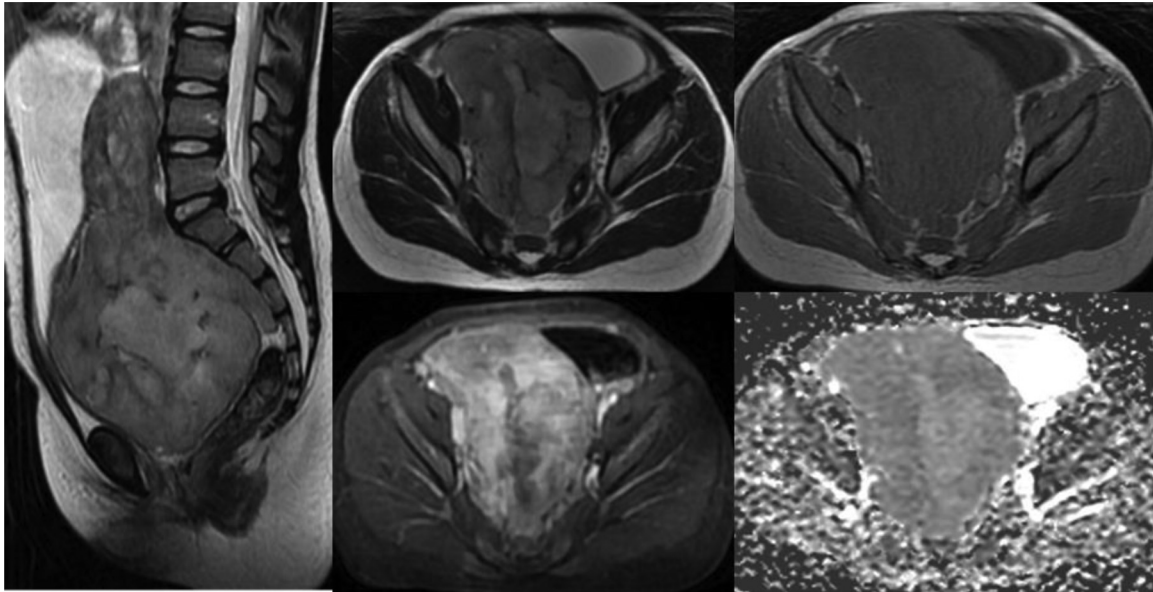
(images 3, 4, 5, 6, 7, and 8): Sagittal T2, axial T2, axial T1, axial T1 MRI after injection of contrast medium, diffusion, ADC mapping, showing a large presacral pelvic mass hypointense on T1, hyperintense on T2 and diffusion without ADC restriction, and heterogeneously enhanced after injection of gadolinium chelates.
